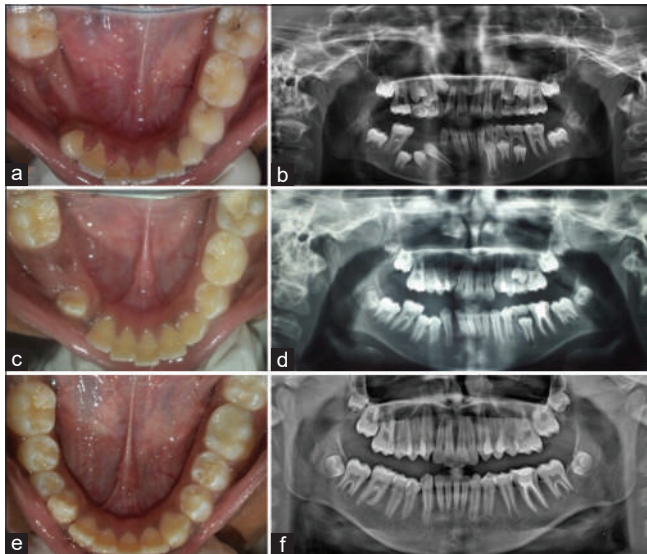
Postoperative clinical and radiographic follow-up showing remarkable reduction in lesion size and eruption of premolars (a and b) After 10 months (c and d) After 2 years (e and f) After 3 years
